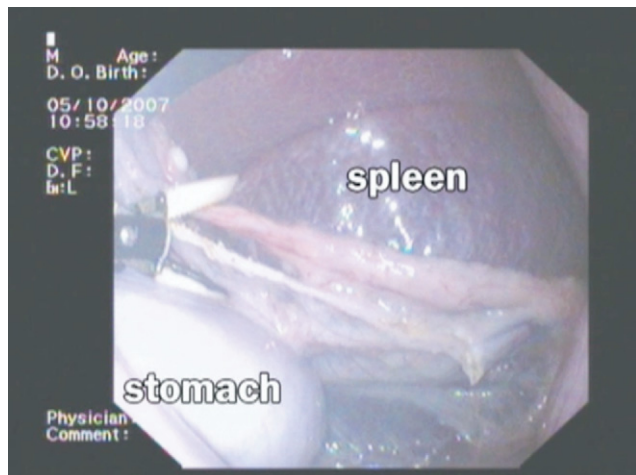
Release, with ultrasonic scalpel, of the gastric great curvature.
